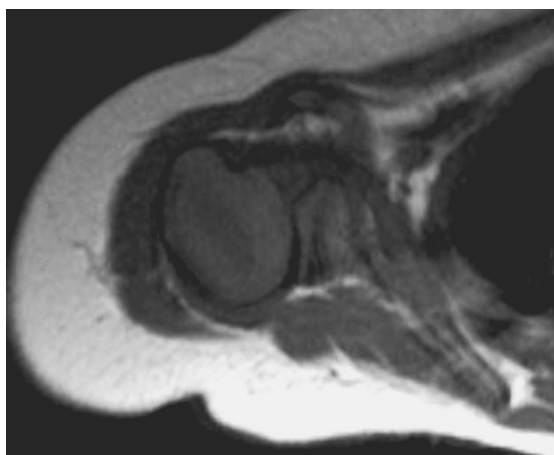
MRI image of the glenohumeral joint with a type 2 subluxation.
